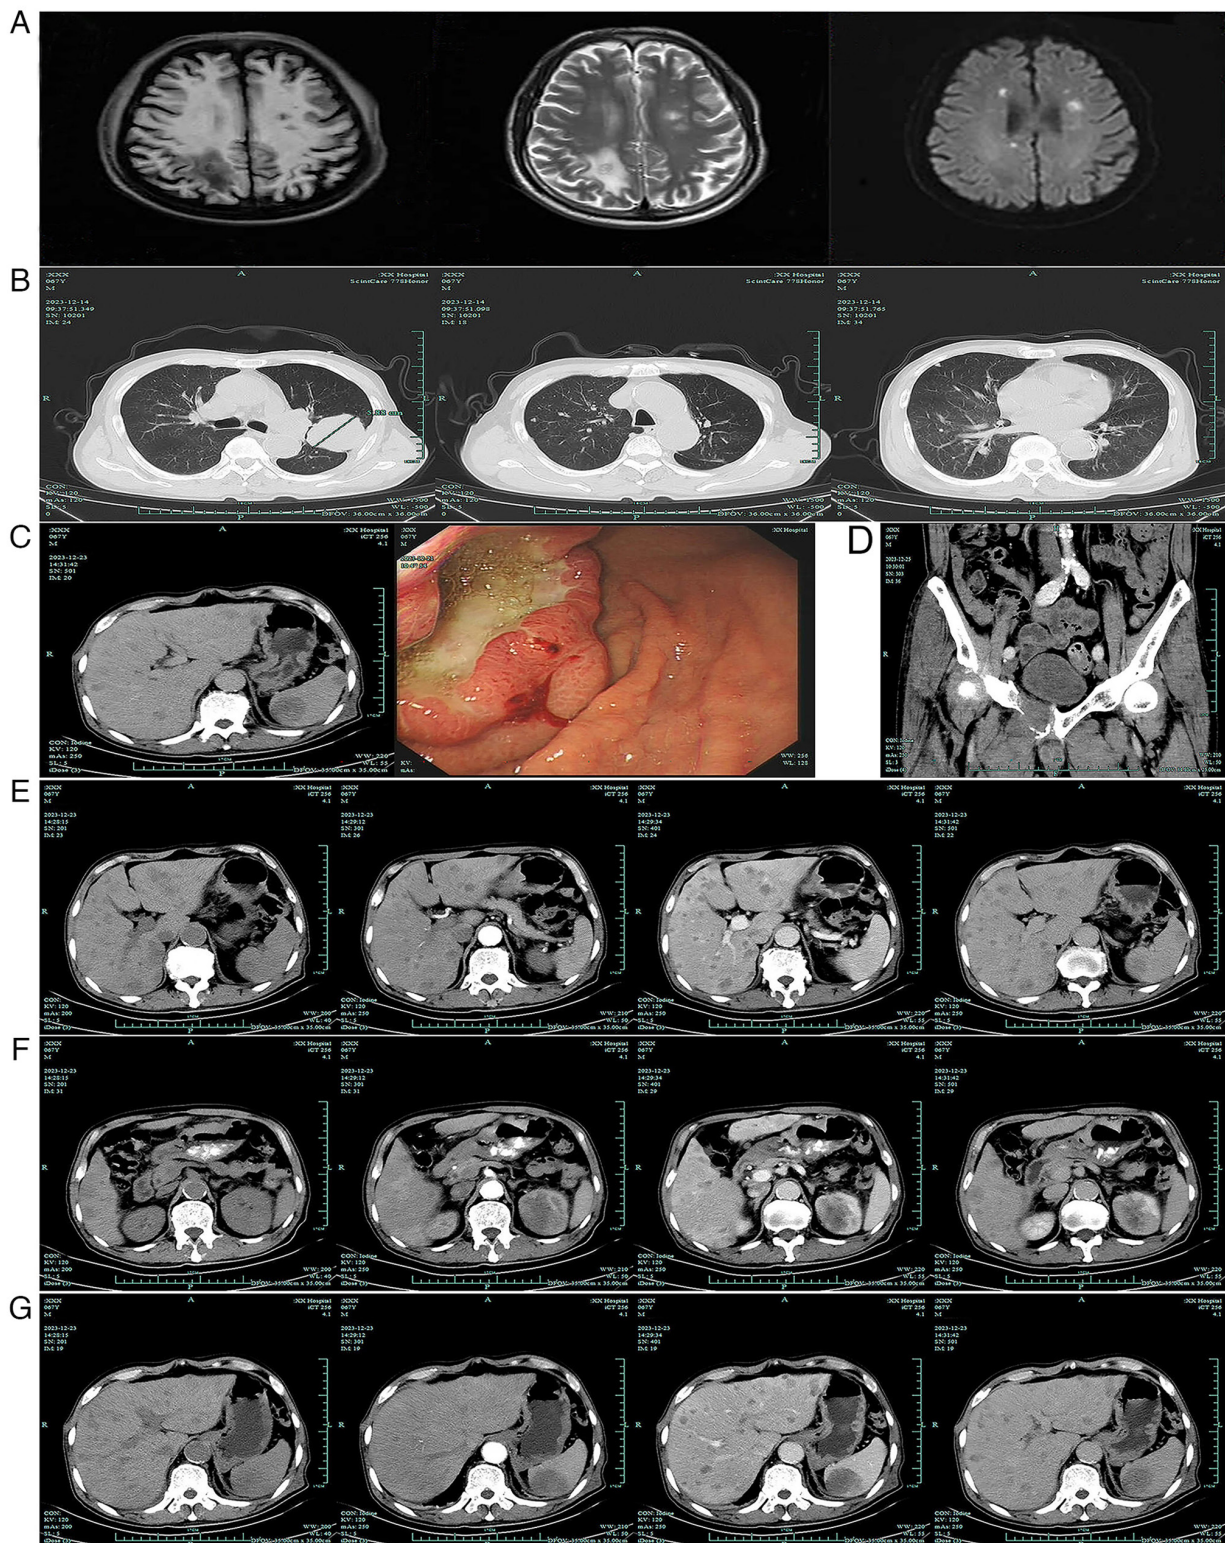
Imaging examinations of the patient on hospital admission. (A) Magnetic resonance imaging of the brain showing multiple nodules in the frontal, parietal and temporal lobes with edema. (B) CT plain scans of the chest showing a 5.88-cm node in the left pulmonary upper lobe invading the pleura and nodular lesions peripherally. (C) CT scan of the abdomen (left panel) showing a heterogeneously-enhanced lesion of the lower part of the gastric corpus and multiple enlarged lymph nodes, and endoscopy (right panel) revealing a huge ulcer located in the lesser curvature of the stomach. (D) CT scan of the pelvis showing bone destruction in the right superior ramus of the pubis. (E) CT scans of the abdomen showing the hepatic lesions, (F) nephritic lesions and (G) splenic lesions. CT, computed tomography.
